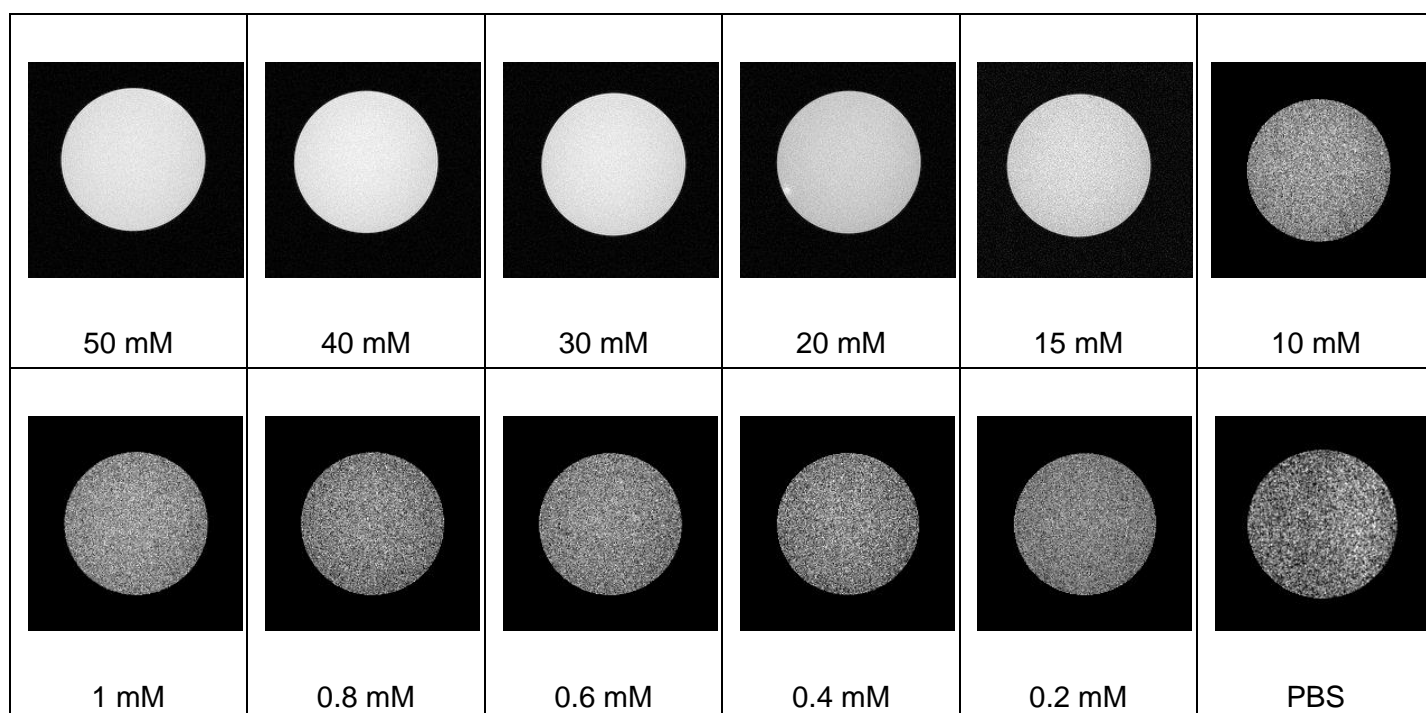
T_1 -weighted MR images for complex 6
